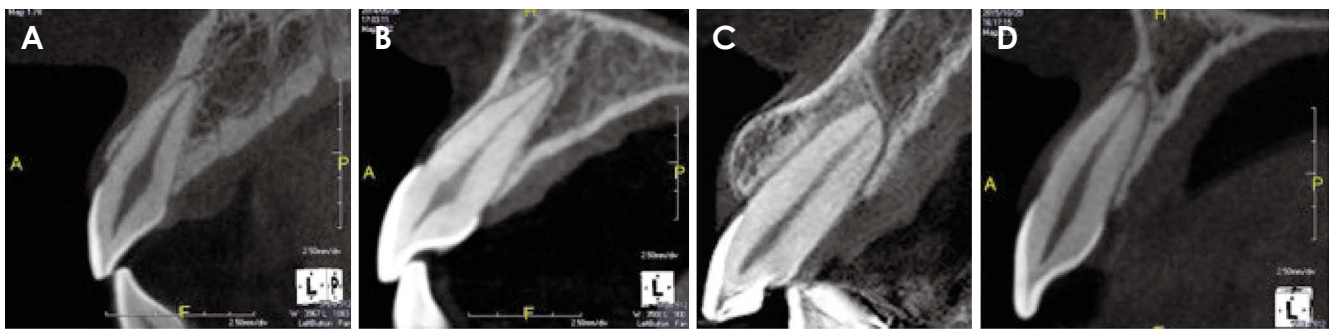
Cone-beam computed tomographic scans of sagittal root position classes. A. Class I. B. Class II. C. Class III. D. Class IV.
